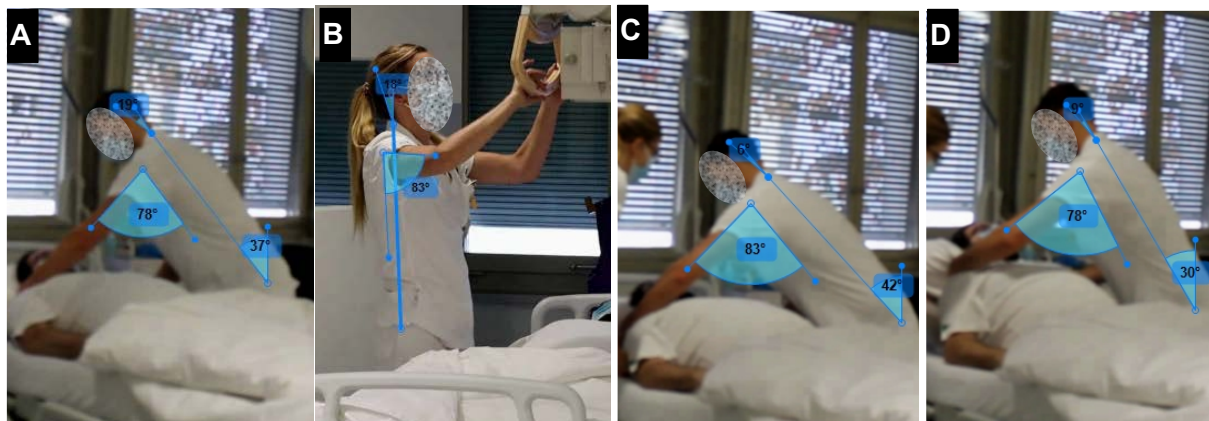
“Not acceptable” postures assumed by the medium (performer) and taller (helper) radiographers during bedside chest X-ray examination scenario 3: a) the taller radiographer during the preparation to position the detector under the patient’s back; b) the medium radiographer during the X-ray tube positioning; c) the taller radiographer during the preparation to remove the detector from under the patient’s back; d) the taller radiographer during the patient handling to remove the detector from under the patient’s back.
